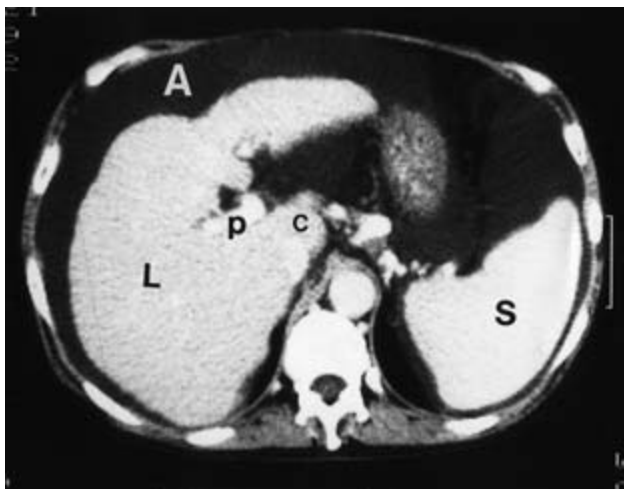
CT scan, after intravenous contrast, in cirrhosis shows ascites (A), small liver with irregular surface (L), enlarged caudate lobe (c), patent portal vein (p) and splenomegaly (S).
